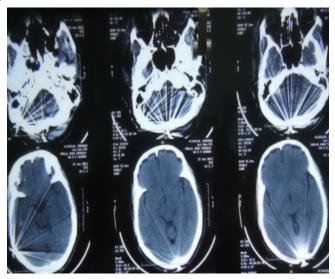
CT scan (Head) of the same patient showing no involvement of brain parenchyma.
